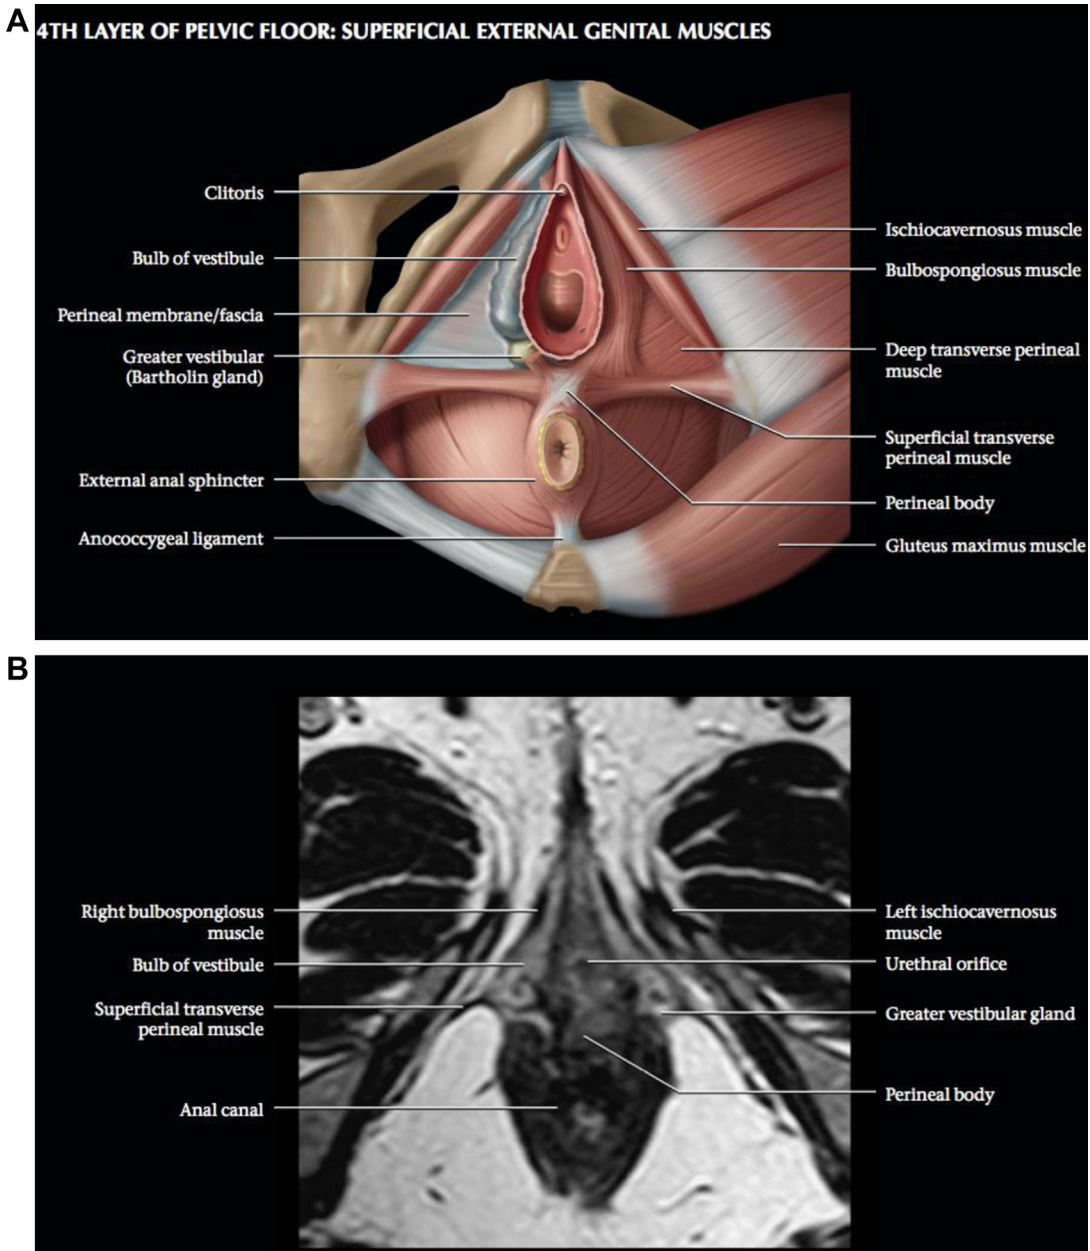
(A) The external genital muscle is located anteriorly in the urogenital triangle, whereas the anal sphincter complex and perineal body are in the anal triangle. The perineal body is a thickened, midline condensation of fibrous tissue at the midpoint of a line joining the ischial tuberosities. At this point, several important muscles converge and are attached: The external anal sphincter, paired bulbospongiosus muscles, paired superficial transverse perineal muscles, and fibers of the levator ani. (B) Axial oblique T2WI MR image in a woman at the level of the superficial external genital muscle shows the extension of the bulbospongiosus muscle. (From [(El Sayed RF . Overview of the Pelvic Floor. In: Shaaban AM, Editor. Diagnostic Imaging: Gynecology 2nd Edition. Philadelphia: Elsevier-Amirsys; 2015. 8/2 -8/28]; with permission.)
